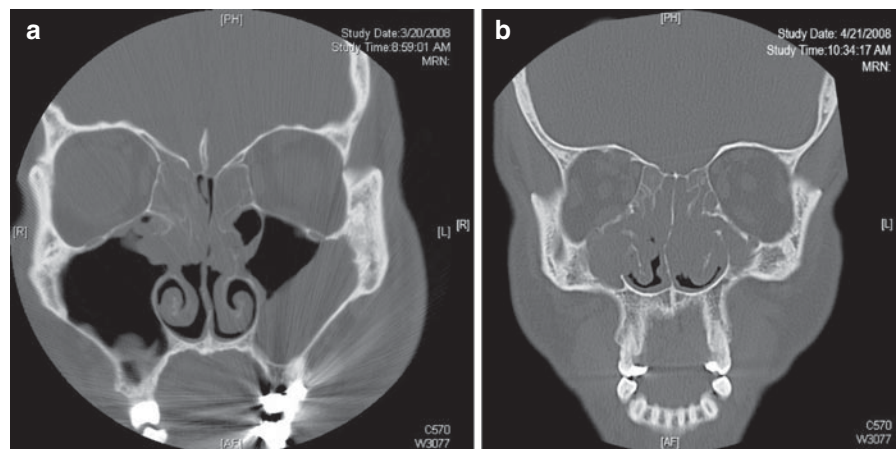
CT images acquired in the axial plane with 1 mm or less slice thickness can be reformatted in coronal and sagittal planes to create triplanar images useful for stereotactic image-guided surgery.
